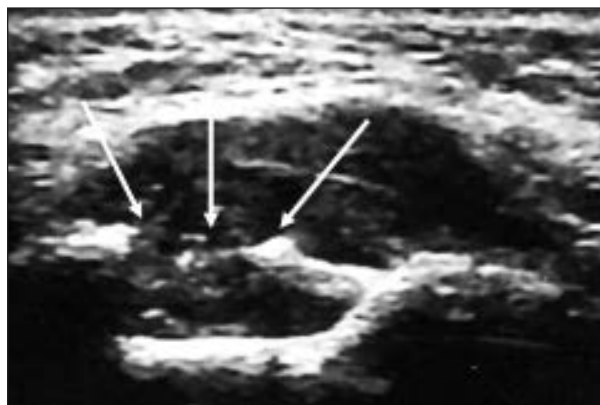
Sonographic investigation in the affected region showing destruction of the vestibular cortical bone by extraosseous manifestation of B-cell lymphoma (white arrows) in Case 4.
